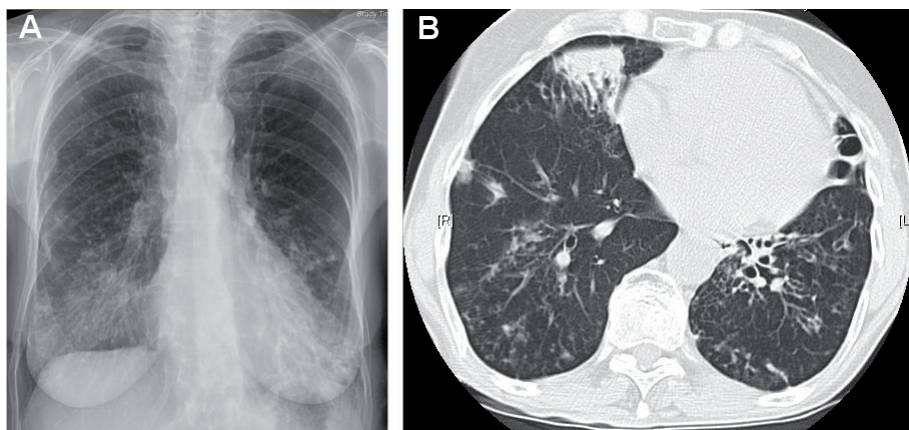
The chest radiograph (A) and corresponding chest CT (B) image of a female patient with pulmonary nodular bronchiectatic *M. intracellulare* disease. Chest radiograph reveals bilateral, predominantly mid to lower lung zone linear and nodular opacities; Chest CT scan reveals peripheral nodular opacities (tree-in-bud pattern), consolidation and bronchiectasis in the right middle lobe, and bronchiectasis in the lingula. Pictures were kindly provided by Professor Charles L. Daley, National Jewish Health, Denver, USA.
